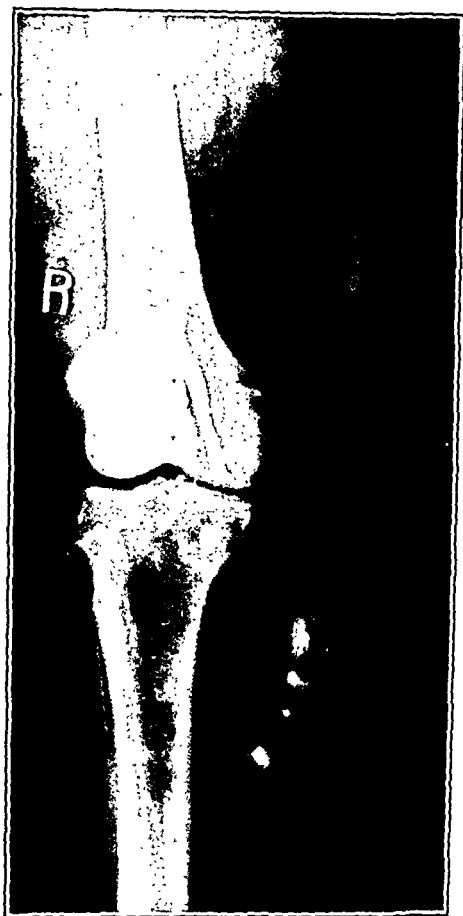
A radiograph with hippuran demonstrating an unsuspected incompetent long saphenous. Visible varices only in lower leg.
